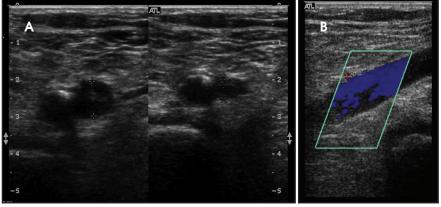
A 69-year-old man with acute left lower extremity edema. Lower extremity sonography from several months earlier (not shown) was normal. Transverse gray scale images (A) without (left) and with (right) compression show partial thrombosis and partial compressibility (calipers) of the left popliteal vein. Sagittal color Doppler image at this level (B) demonstrates partial thrombosis of the posterior portion of the vein.
